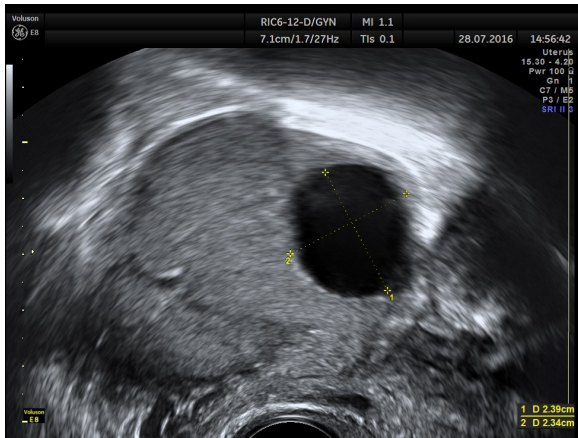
Transvaginal ultrasound image of a solid benign Brenner tumor containing an anechoic cystic component described as malignant by sonographer
